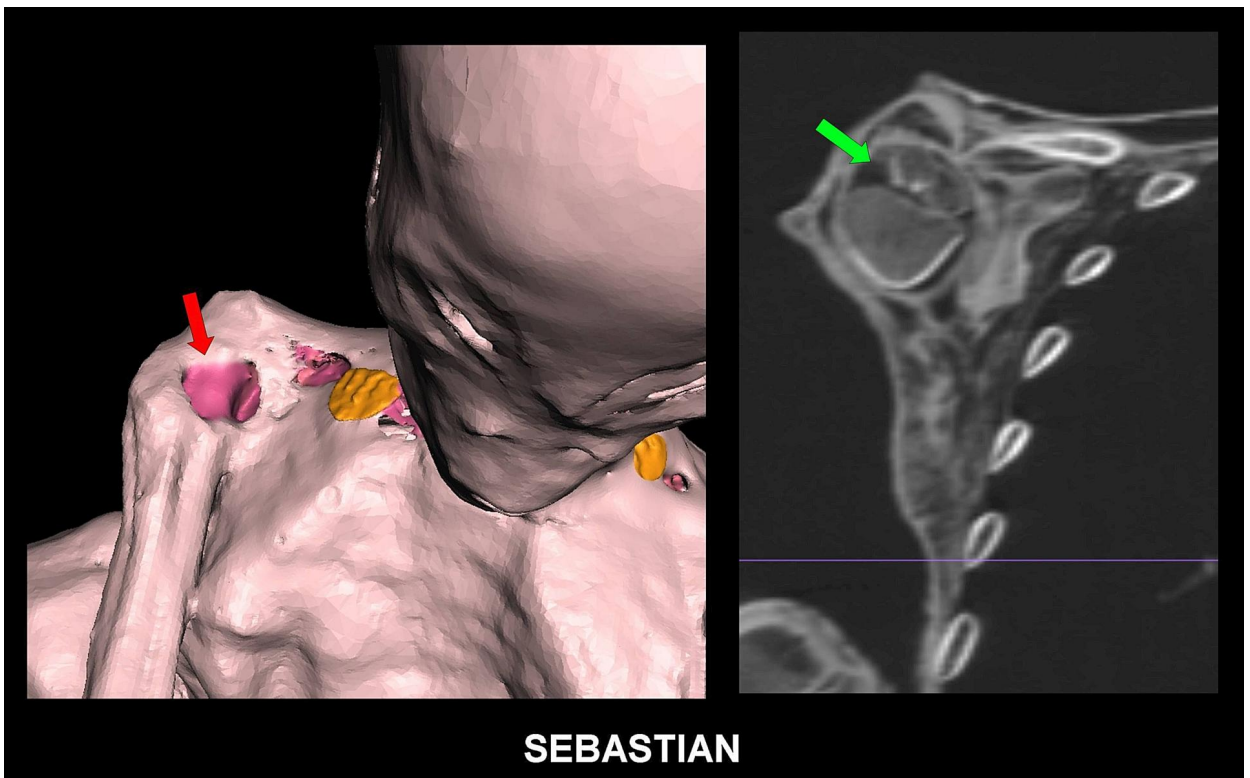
3D CT (*left*) showing tissue loss (*red arrow*) over anterior medial aspect of right shoulder. Underlying destruction in lateral part of right upper humeral epiphysis (*green arrow*) can be found on 2D coronal CT scan (*right*).
